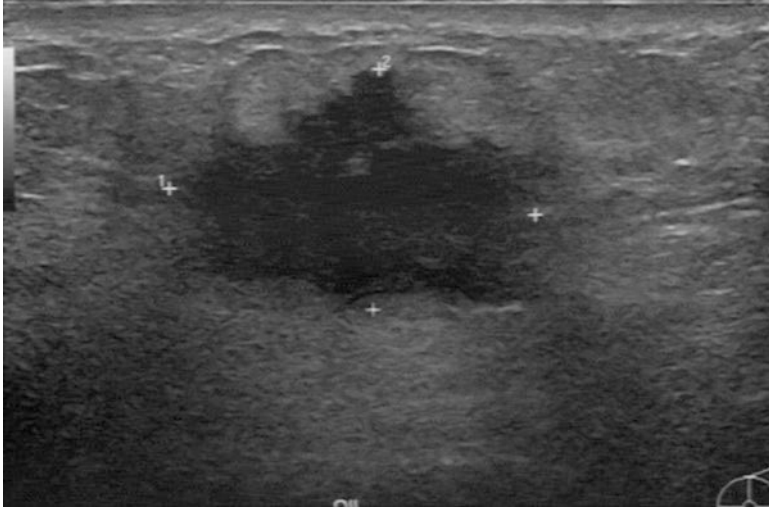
Breast ultrasound image
